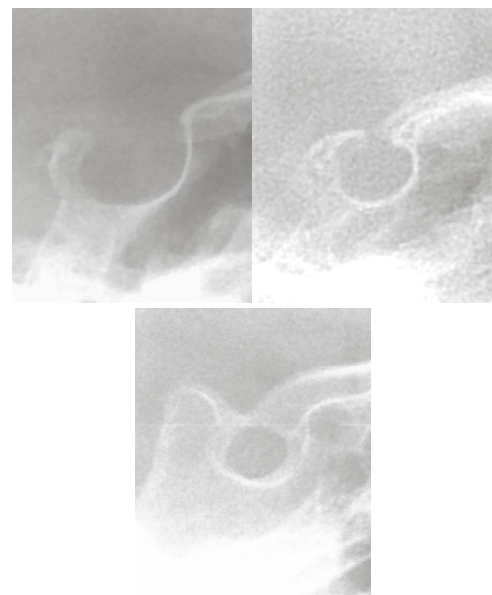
Radiographical appearance of Sella Turcica Bridging
